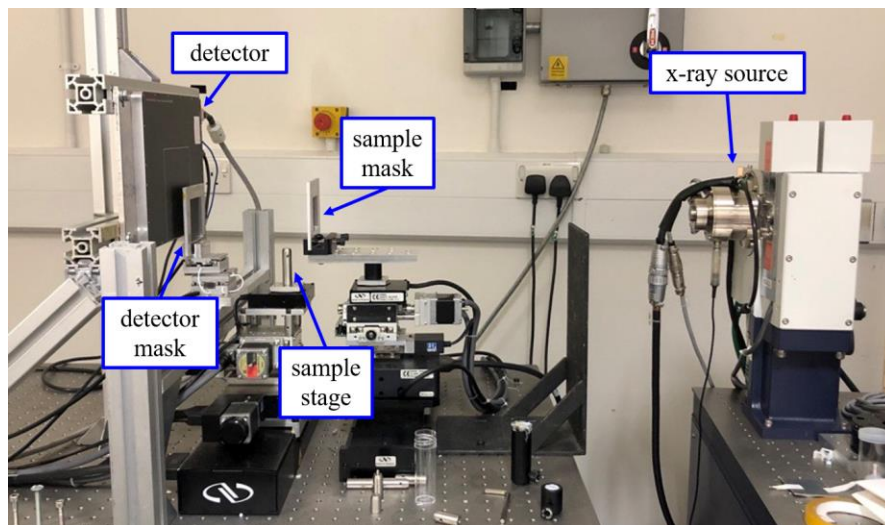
Photograph of the EI x-ray phase contrast imaging setup at UCL.
